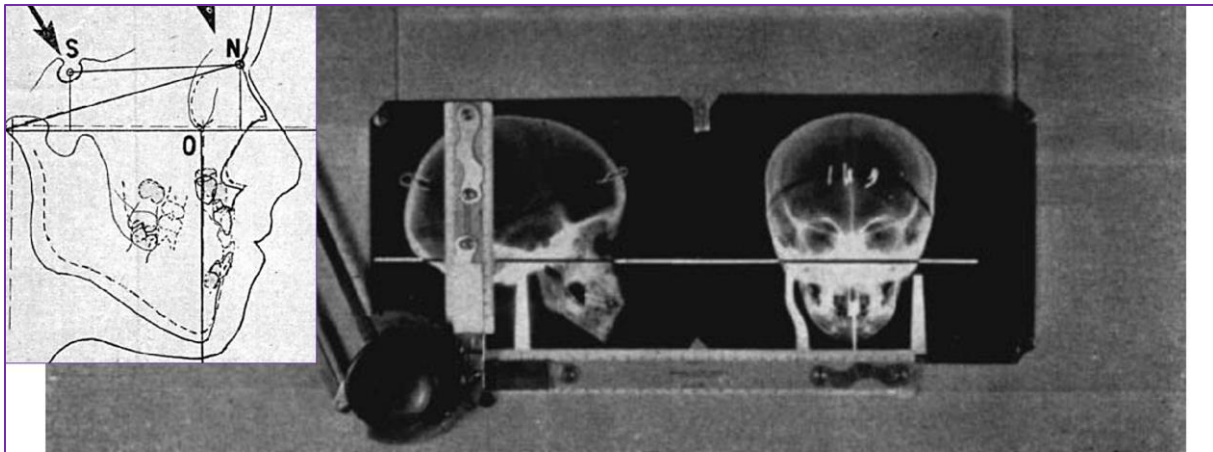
Frontal and lateral roentgenograms in place for measurement on a trans-illuminated drafting table fitted with the Universal drafting machine.
